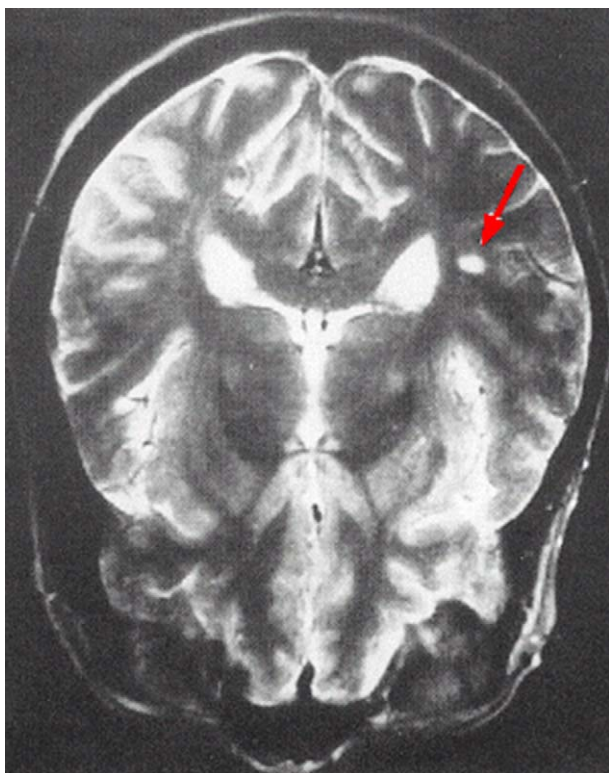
Magnetic resonance imaging showing an ischemic brain lesion (arrow) in a patient with normal-tension glaucoma.
